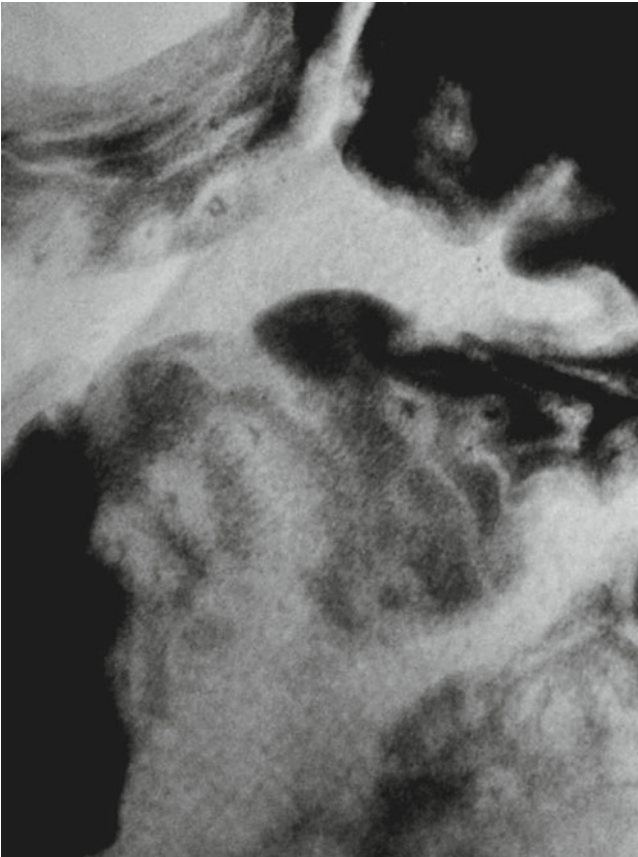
Case 4: Endoscopy and radiography performed at around the same time revealed multiple aphthae allined longitudinally from the middle small intestine to the terminal ileum
